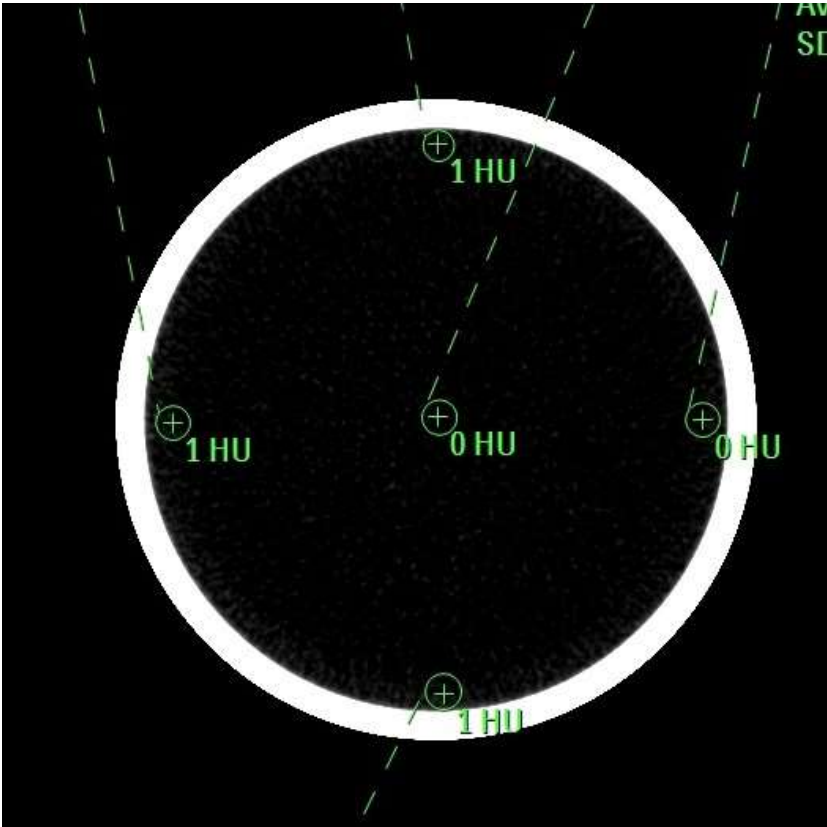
CT number uniformity
